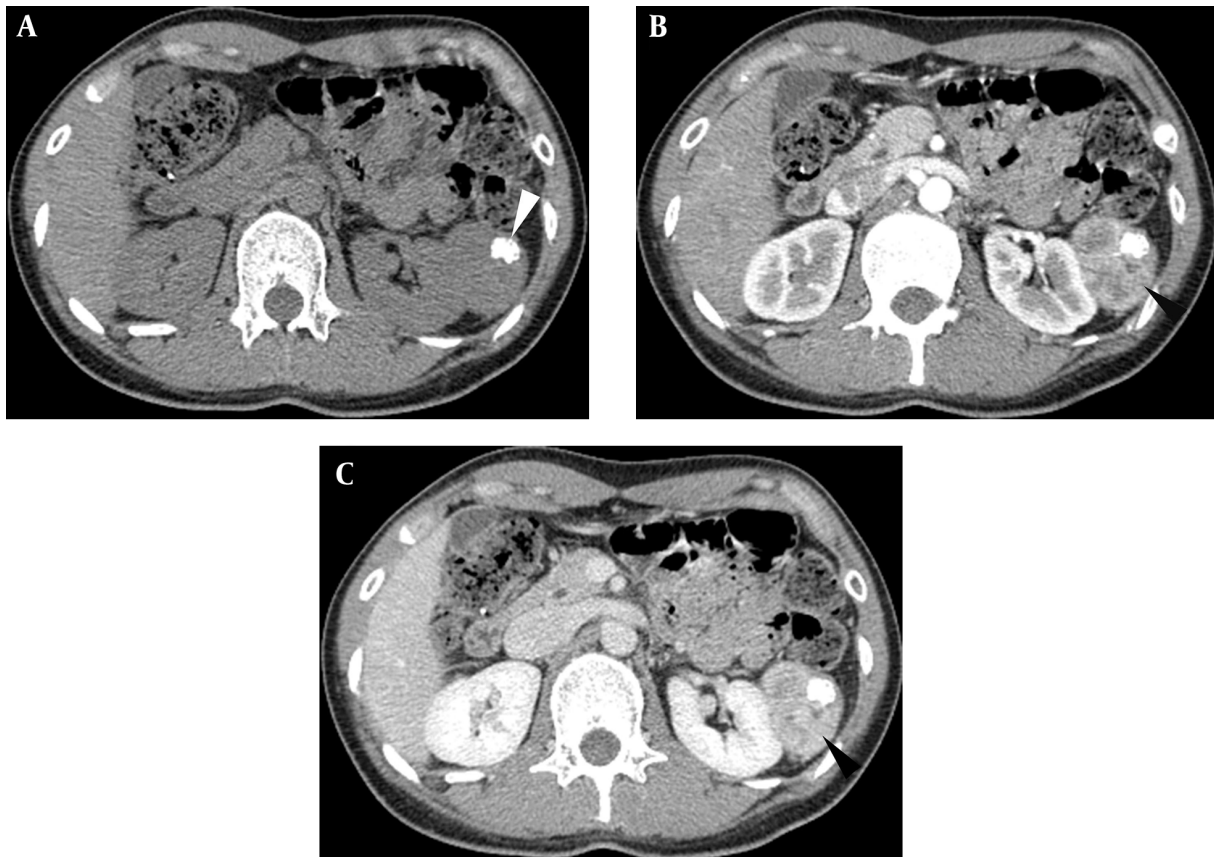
Axial CT images. A, Homogeneous iso-attenuation mass with nodular calcification (white arrowhead) is detected on plain scan; B, Parenchyma of the mass shows enhancement (black arrowhead) in the arterial phase and C, Vivid enhancement (black arrowhead) in the portal phase.
